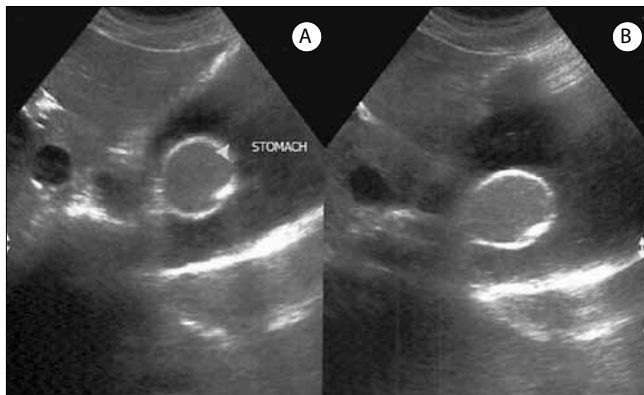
Ultrasonographic images showing a circumscribed cystic lesion (arrowhead) with a partially calcified wall attached to the anterior wall of the lesser curvature.
